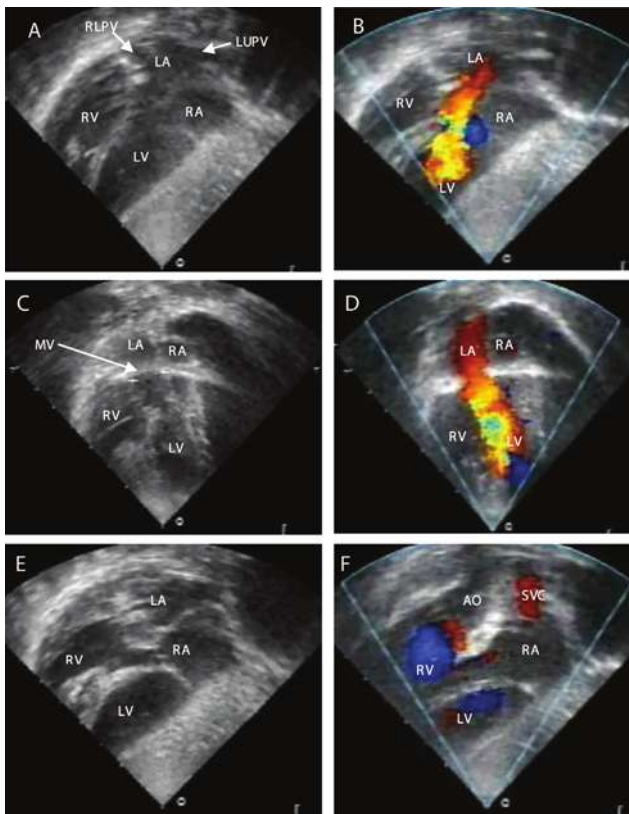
Subcostal 4 - chamber view in patient with dextrocardia situs inversus, AV concordance connection with criss-cross AV relation : A. the pulmonary veins LV drained into the LA on the right side which connected to the smooth trabecular LV on the left side, B. color Doppler clearly showed the direction of blood streams from LA on the right side to LV contralaterally through small mitral valve. It can also be visualized through apical 4 - chamber view (C, D).
